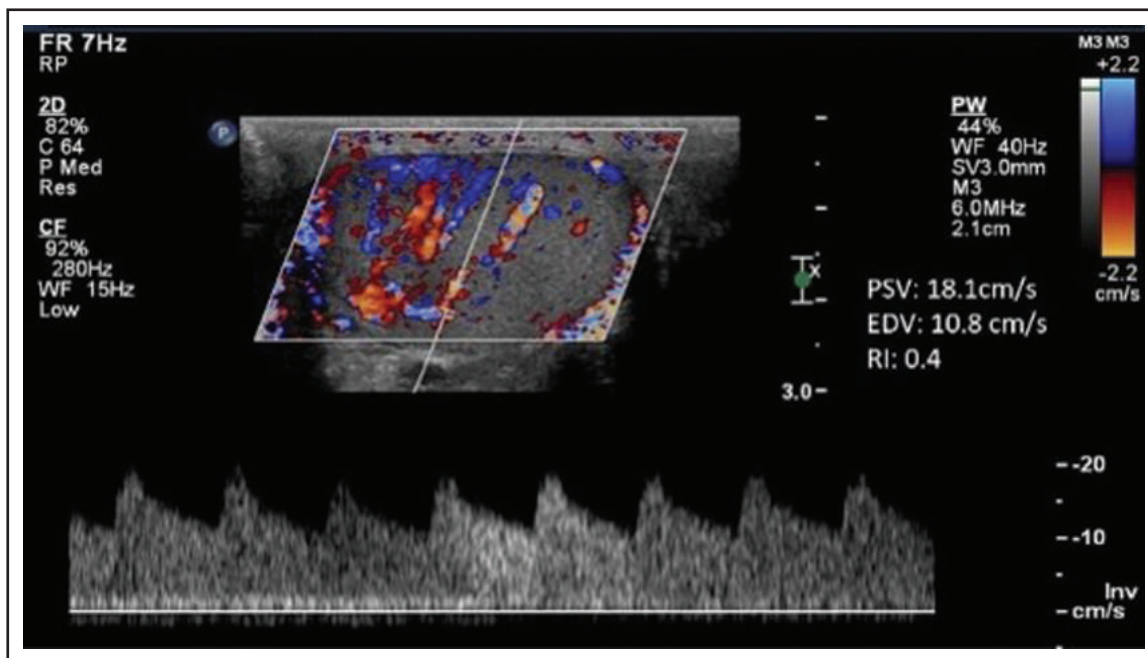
Abnormal spectral doppler waveform in early EO. Spectral waveform demonstrating an increased PS and EDV with a decreased RI: 0.4.
